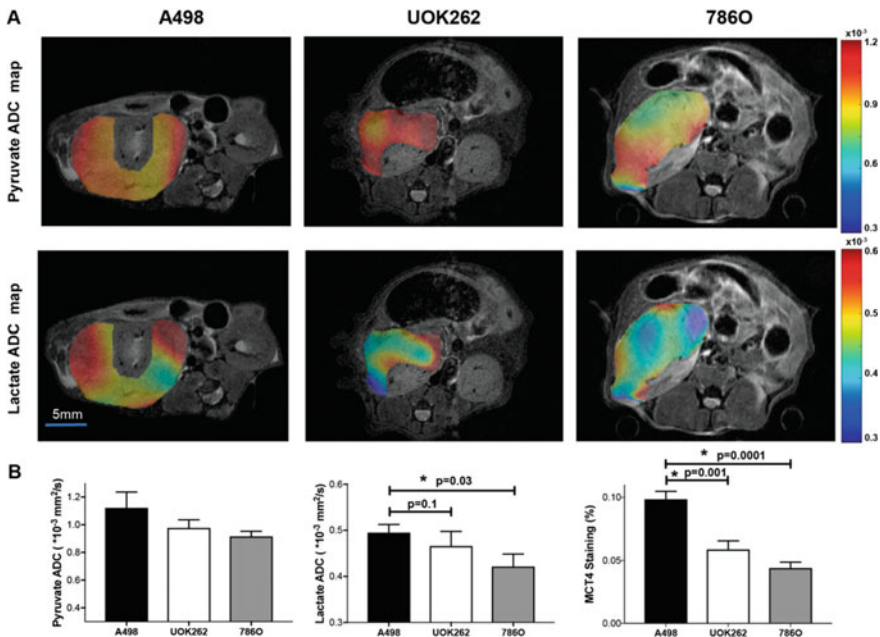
Hyperpolarized (HP) ^{13}C pyruvate MRI showing differences in lactate production and compartmentalization of orthotopic renal cell carcinoma tumors. a ^{13}C pyruvate and ^{13}C lactate ADC maps from diffusion-weighted HP ^{13}C MRI overlaid on the T2-weighted anatomic images. b The ^{13}C pyruvate, ^{13}C lactate, and monocarboxylate transporter 4 (MCT4). The levels of lactate appear to correspond to the different levels of MCT4 which mediates lactate export out of tumor cells. Reprinted with permission under the Creative Commons Attribution License from Sriram et al., Non-Invasive Assessment of Lactate Production and Compartmentalization in Renal Cell Carcinomas Using Hyperpolarized ^{13}C Pyruvate MRI, *Cancers* 10(9), pp 13 (2018)
